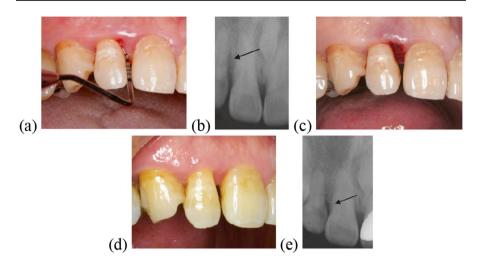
a Deep pockets present on the lateral incisor with one of them measuring 8 mm with bleeding on probing. b Radiograph showing vertical bony defect (black arrow). c Immediate postoperative view showing a stable blood clot. The Er:YAG laser was used with a 600 μ m curved tip at 1.0 W average power (50 mJ/pulse at 20 Hz) with a water spray to remove inflamed soft tissue in the pocket along with a curette to debride the root surface. The inner epithelial wall and the bone defect were also debrided. The outer epithelium was recontoured without a water spray to delay gingival down growth and a stable blood clot was formed. d 1-Year postoperative view showing good healing with 2 mm probing pocket depth with a slight loss of the gingival papilla. e Radiograph confirming the filled bone defect (black arrow) (Graphic modified from Mizutani et al. (reference #3) with permission © copyright 2016 John Wiley and Sons A/S)
